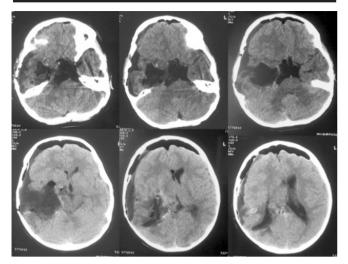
The postoperative CT scan of the patient showing total resection of the tumor.
